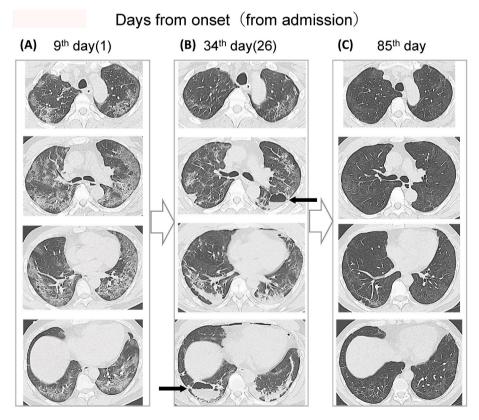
Findings of Chest CT scan. Chest CT performed on admission (A: on the 9th day from onset), after drainage of pneumothorax (B: on the 34th day), and 1 month after discharge (C: on the 85th day). Pneumatocele formations were found on the both lower lobe (B: indicated as the black arrow).
